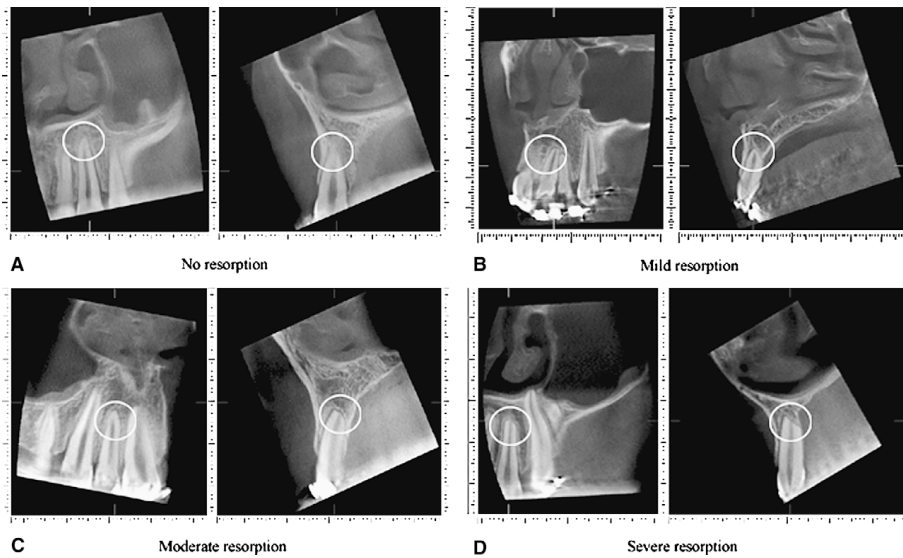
(A) Index for evaluation of root resorption in the CBCT: A, 0, no resorption in tooth 22; B, 1, mild resorption in tooth 21; C, 2, moderate resorption in tooth 12; D, 3, severe resorption in tooth 22.
